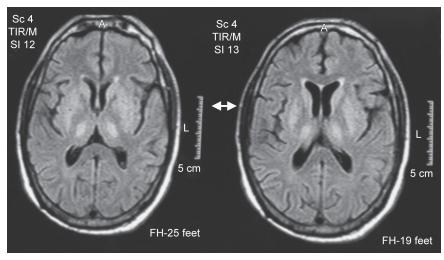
Brain MRI on coronal flair T2-weighted images showing hyperintensities in thalamus and basal ganglia
